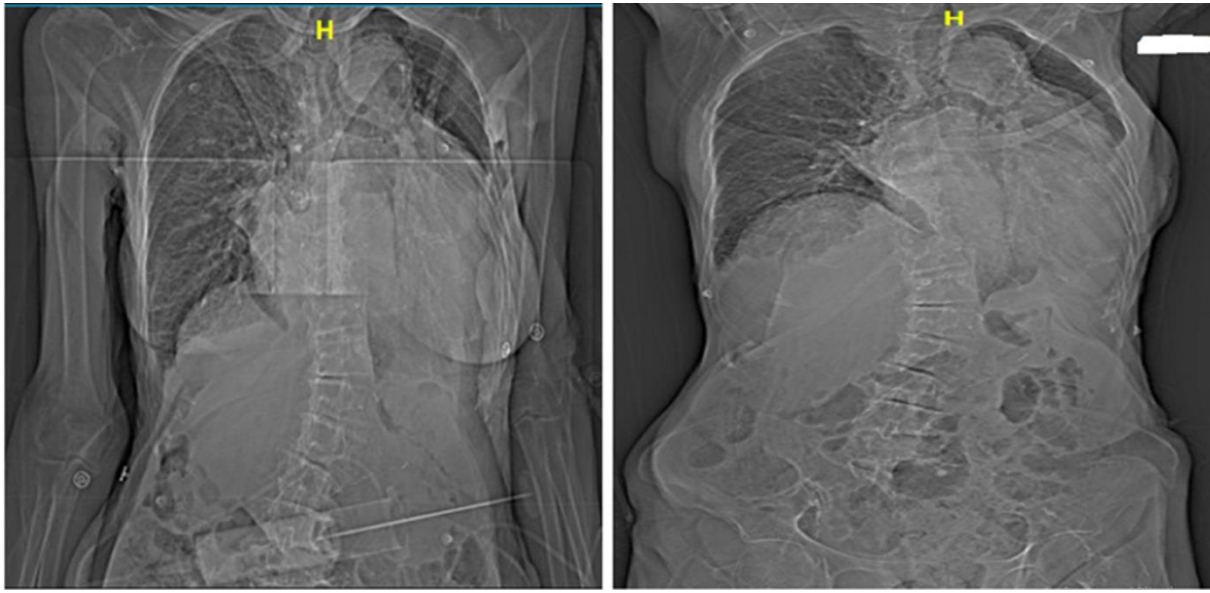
The patient's chest X-ray shows a widened mediastinum and cardiomegaly, along with a blunted left costophrenic angle.
